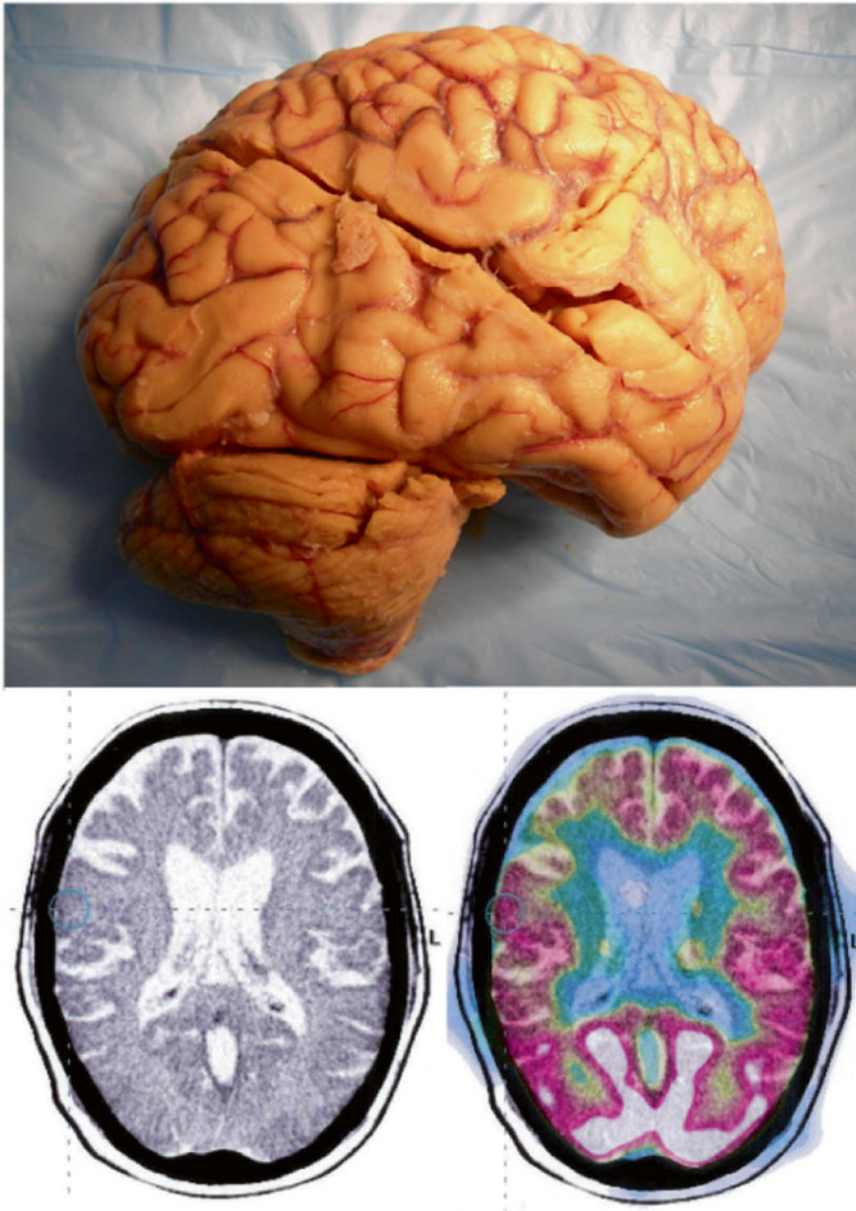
Frontotemporal dementia: PET detection of right frontal hypometabolism with corresponding right frontal atrophy seen on CT and later at autopsy
